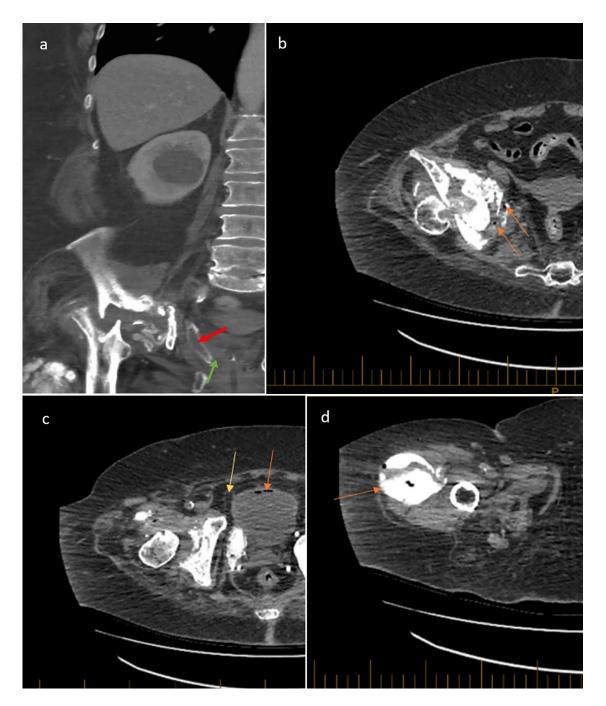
CT findings of Mrs F's presentation in 2022 are demonstrated.
